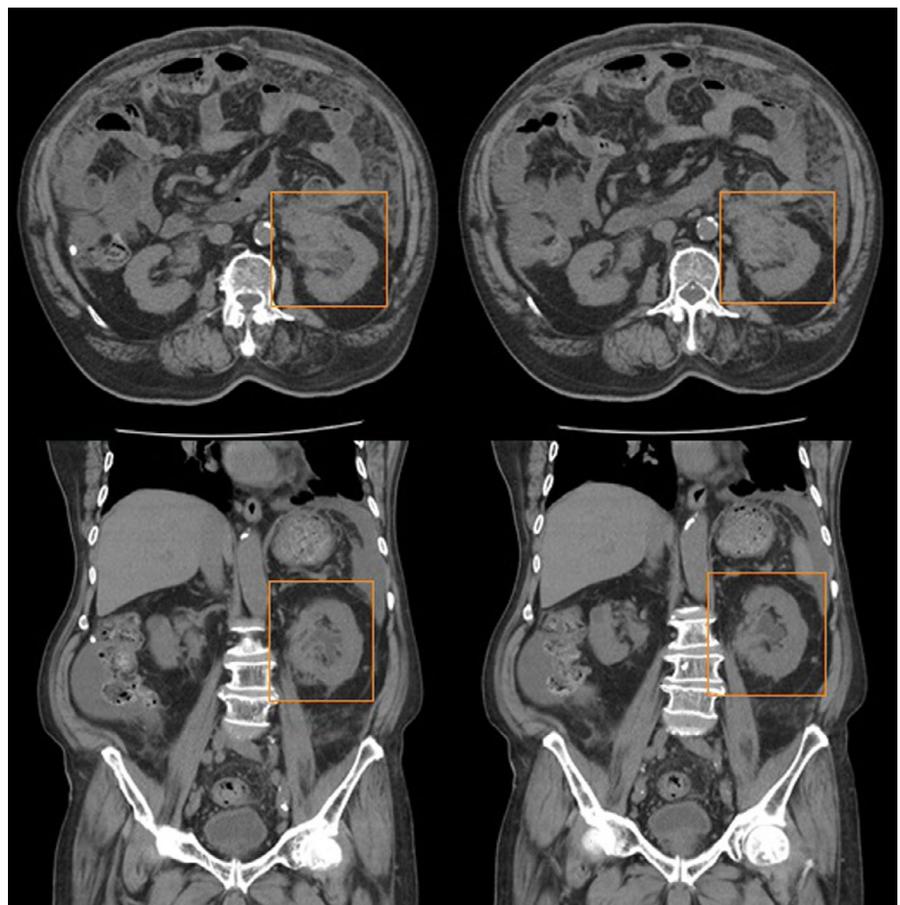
Computed tomography (CT). Computed tomography (CT). A CT image reveals a suspicious renal pelvis tumor with hydronephrosis
